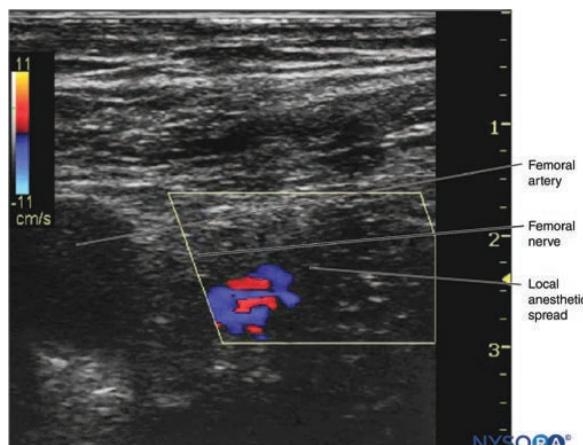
Catheter tip detection using the spread of the injectate and color Doppler imaging.
